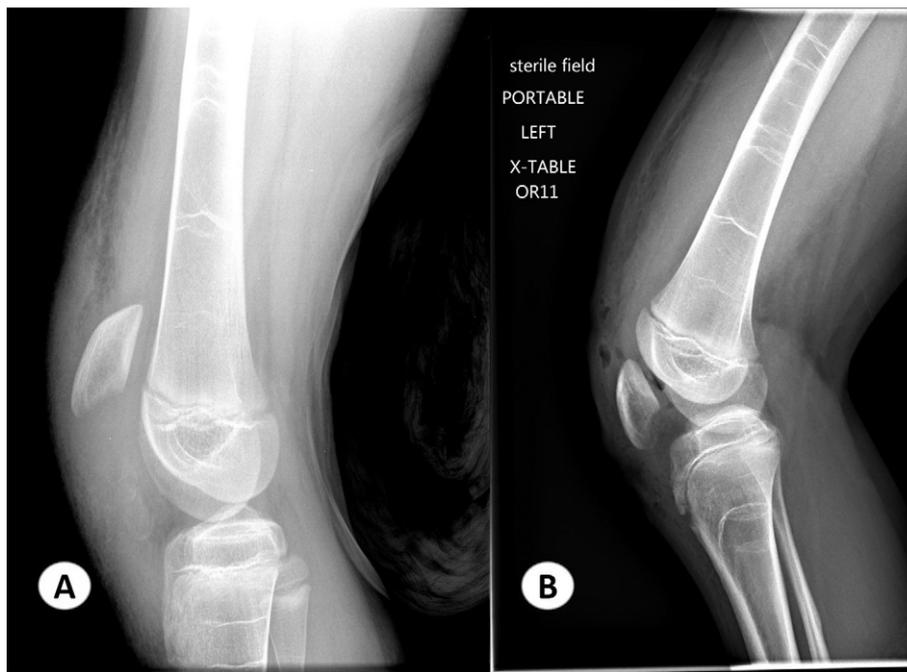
A) Preoperative lateral X-ray knee shows high riding patella with patella tilting due to patella tendon rupture. B) Intraoperative lateral view reveals low lying patella (patella baja) with decreased Insall–Salvati ratio due to over tightness of patellar tendon repair.
